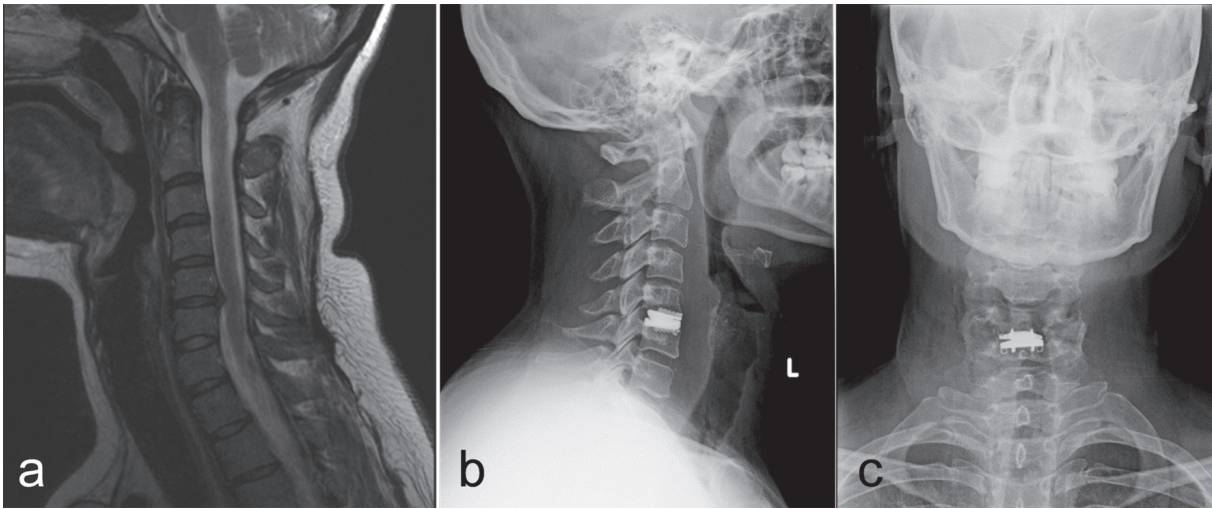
Preoperative MRI (a) and postoperative x-rays (b, c) of a patient with Prestige disc prosthesis.
